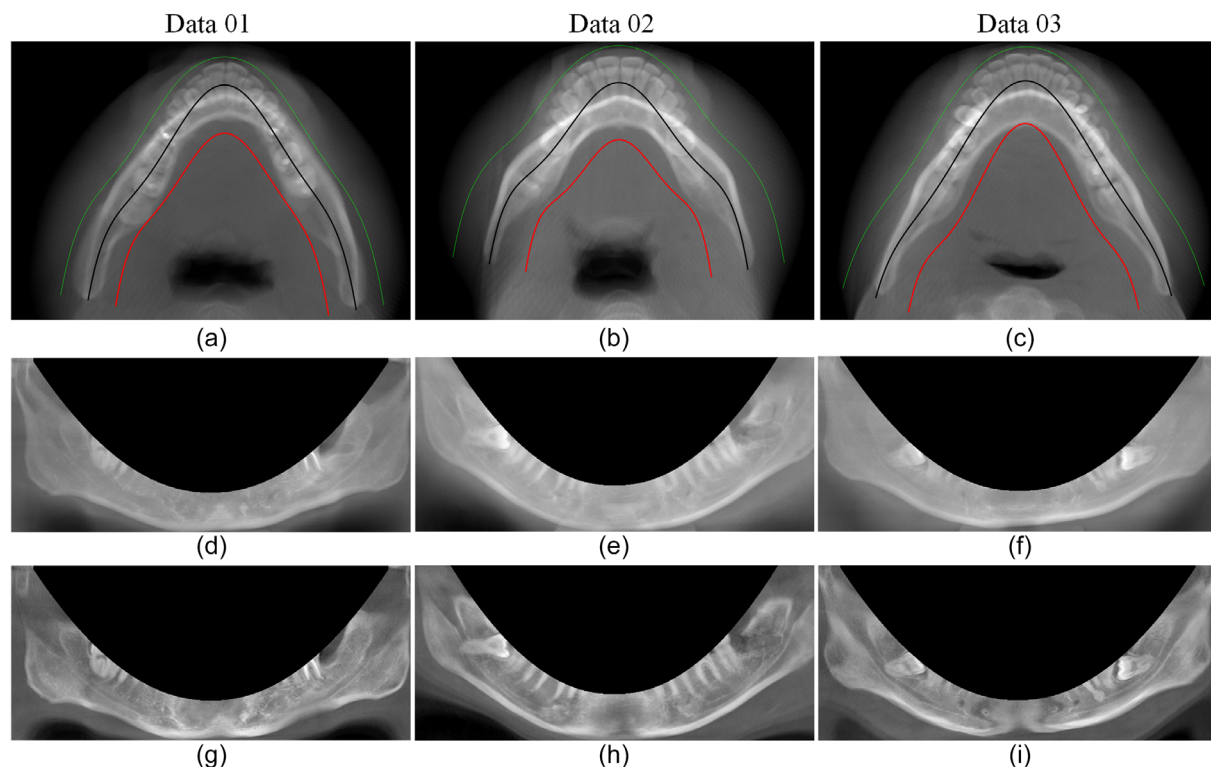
Reconstruction results of the three CBCT sets. (a–c) The fitting results of the curves. The black curves are the dental arch curves; the green and red curves are the upper and lower edge curves, respectively. (d–f) The total AIP panorama images. (g–i) The new panoramas with the proposed method
